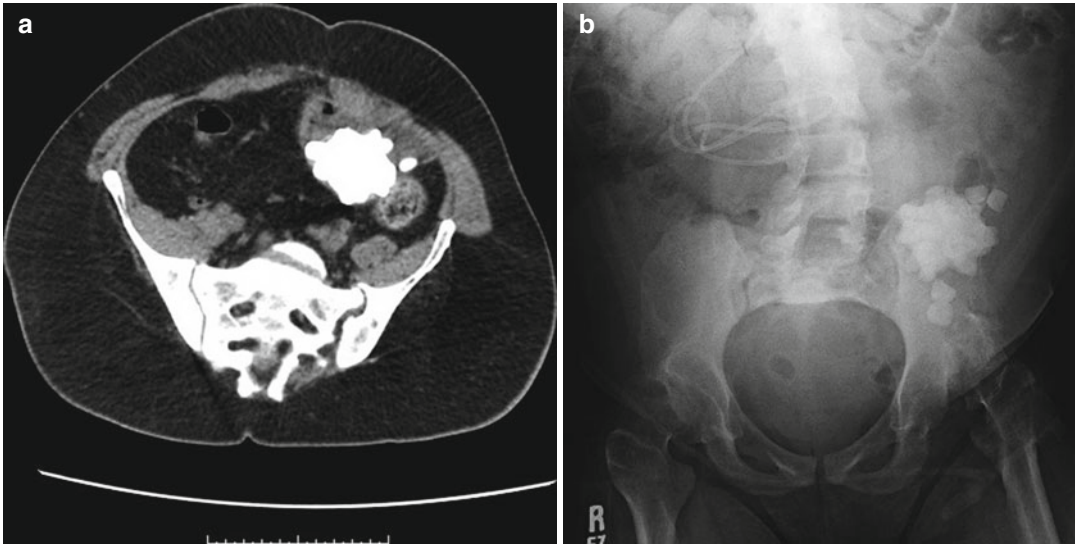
Axial CT scan image (a) demonstrating multiple stones within an augmented bladder; KUB (b) demonstrates that the stone is radiopaque. Following removal
